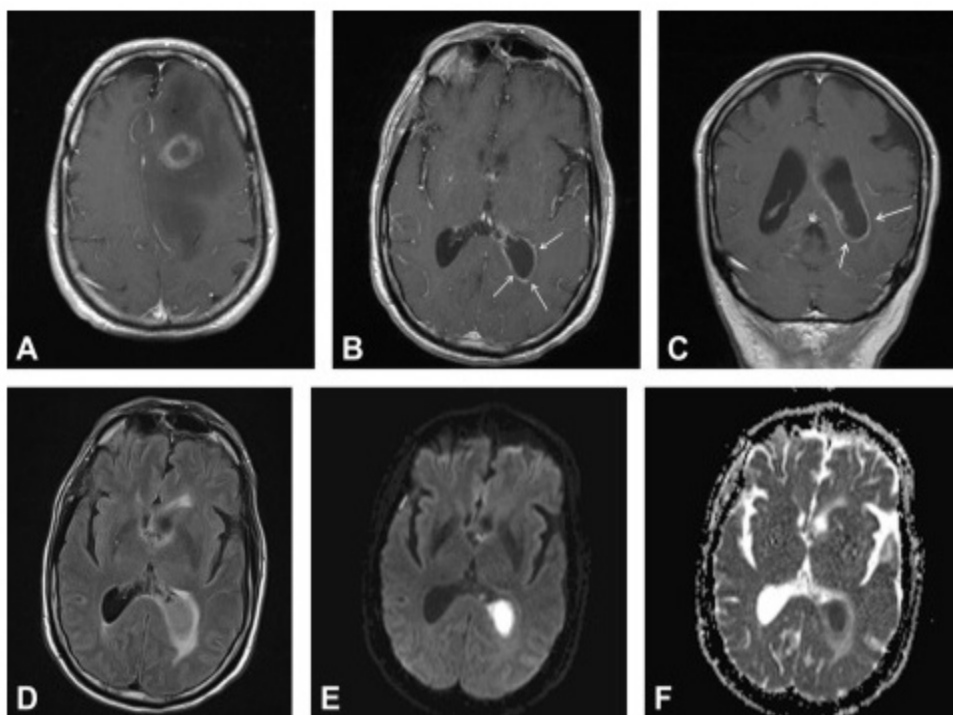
A 70-year old man with known intracranial abscess with rupture into the left ventricle. (A) Axial T1-weighted postcontrast magnetic resonance (MR) image demonstrates a mass with thick and irregular ring enhancement in the medial left frontal lobe, just above the body of the left lateral ventricle, consistent with a brain abscess. T1-weighted postcontrast axial (B) and coronal (C), axial fluid-attenuated inversion recovery (FLAIR) (D) and axial diffusion (E) and apparent diffusion coefficient (F) MR images at the level of the atrium of the lateral ventricle demonstrate restricted diffusion within the dependent portion of the occipital horn of the left lateral ventricle with associated ependymal enhancement (arrows), consistent with ventriculitis. The adjacent brain parenchyma demonstrates significant FLAIR signal hyperintensity, consistent with vasogenic edema.
